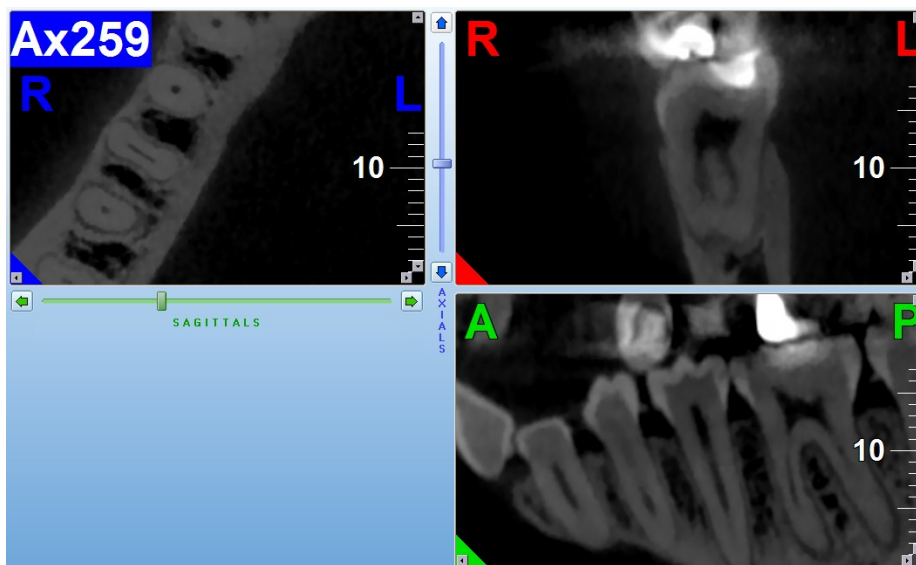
Axial, coronal and sagittal view of CBCT image, showing isthmus in mesial root
